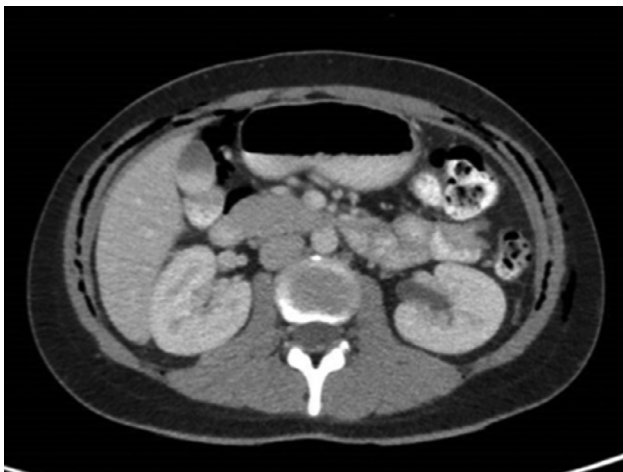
Axial cut of CT Abdomen on POD2 showing air collection around the stomach and duodenum as well as subcutaneous emphysema
